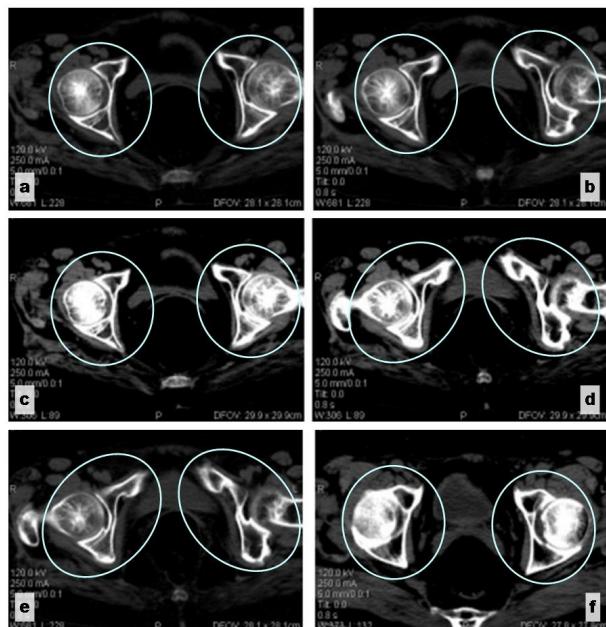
CT axial serial sections of hip joint.
